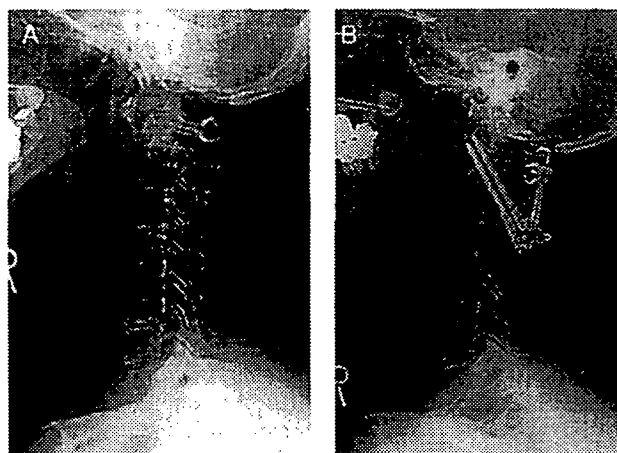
A, Preoperative lateral neutral radiograph of 56-year-old woman. Slight subluxation and facet erosion were found at C4-C5. B, C1-C2 angle decreased by 7 degrees postoperatively. Four years after surgery, marked subluxation and angular deformity were developed at C4-C5.
